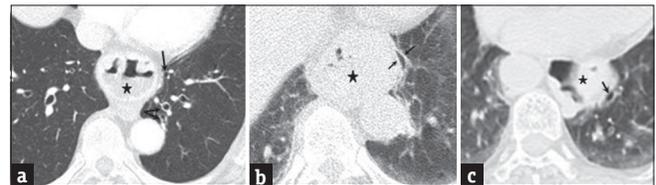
Axial chest CT images of different patients in lung window (a-c) show hiatal hernias (stars) with adjacent bronchiectasis (arrows)
